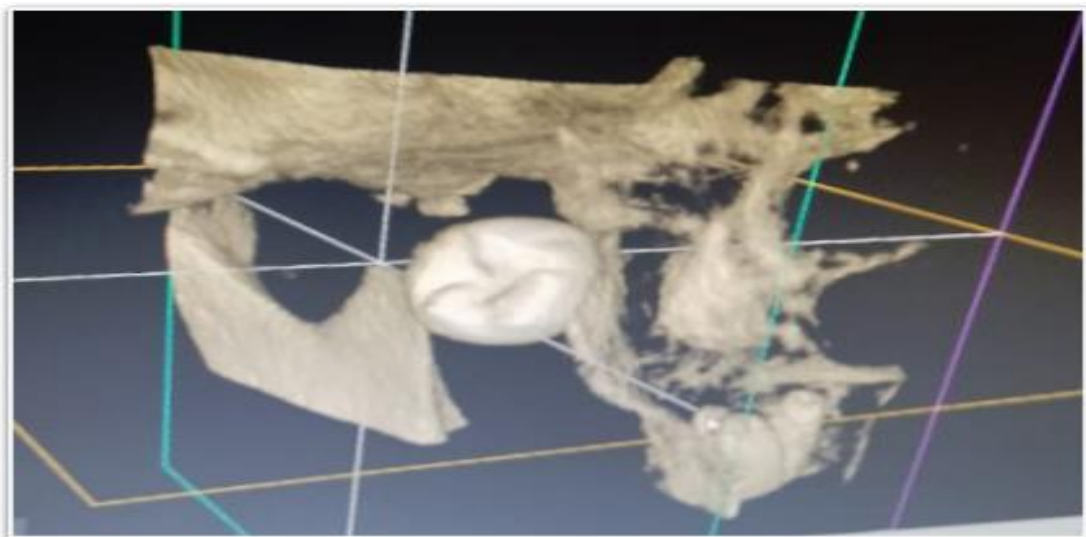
3D CBCT shows the displaced third molar just anterior to the coronoid
